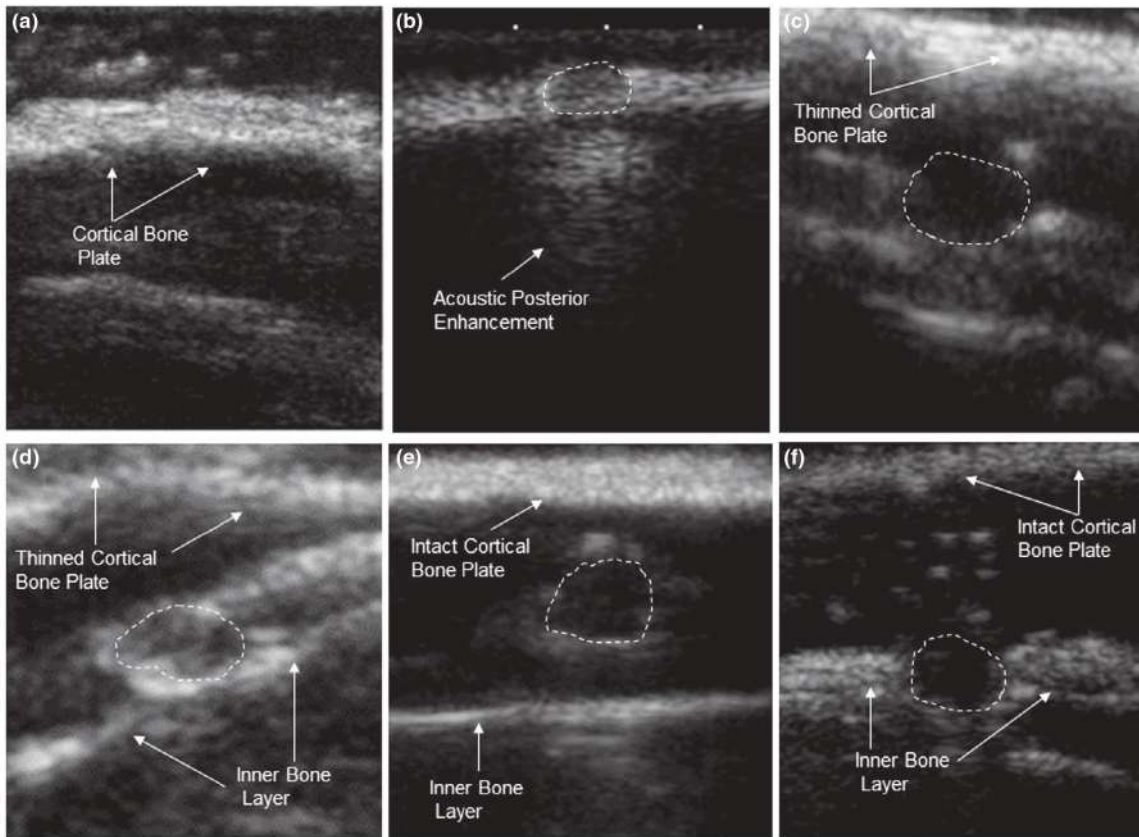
Echographic images of the six experimental groups: (a) NCG ultrasound scanning showing the absence of lesions and a highly reflecting cortical bone plate (arrowed); (b) PCG ultrasound image showing a hypoechoic 0.2 mm lesion (circled) perforating the cortical bone plate and producing an acoustic posterior enhancement (arrowed); (c) SG1 and (d) SG2 ultrasound scans showing the thinned outer cortical plate (arrowed) and the hypoechoic experimental lesions (circled) delimited by the inner bone layer (arrowed); (e) SG3 and (f) SG4 ultrasound scans showing the intact cortical plate (arrowed) and the hypoechoic experimental lesions (circled) delimited by the inner bone layer (arrowed).
